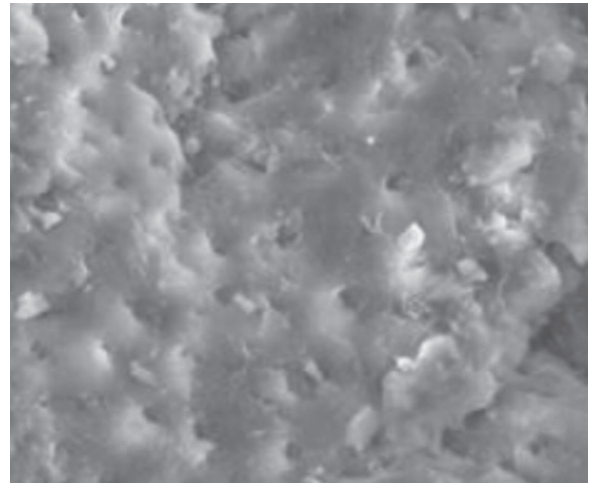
Ultrasonic group apical level (score 3)
